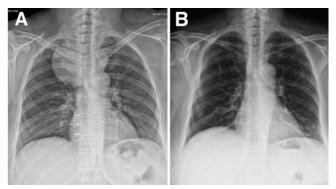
Posteroanterior chest radiograph showing increased opacity in the paratracheal area and mediastinal enlargement in the right upper zone (A); Post-thoracotomy chest X-ray of the patient (B)
